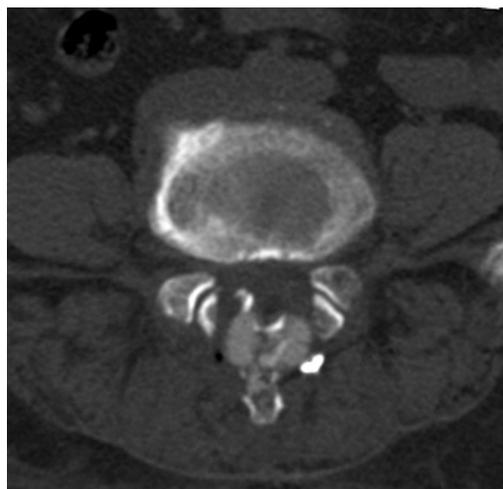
Computed tomography showing spinous process fracture.
